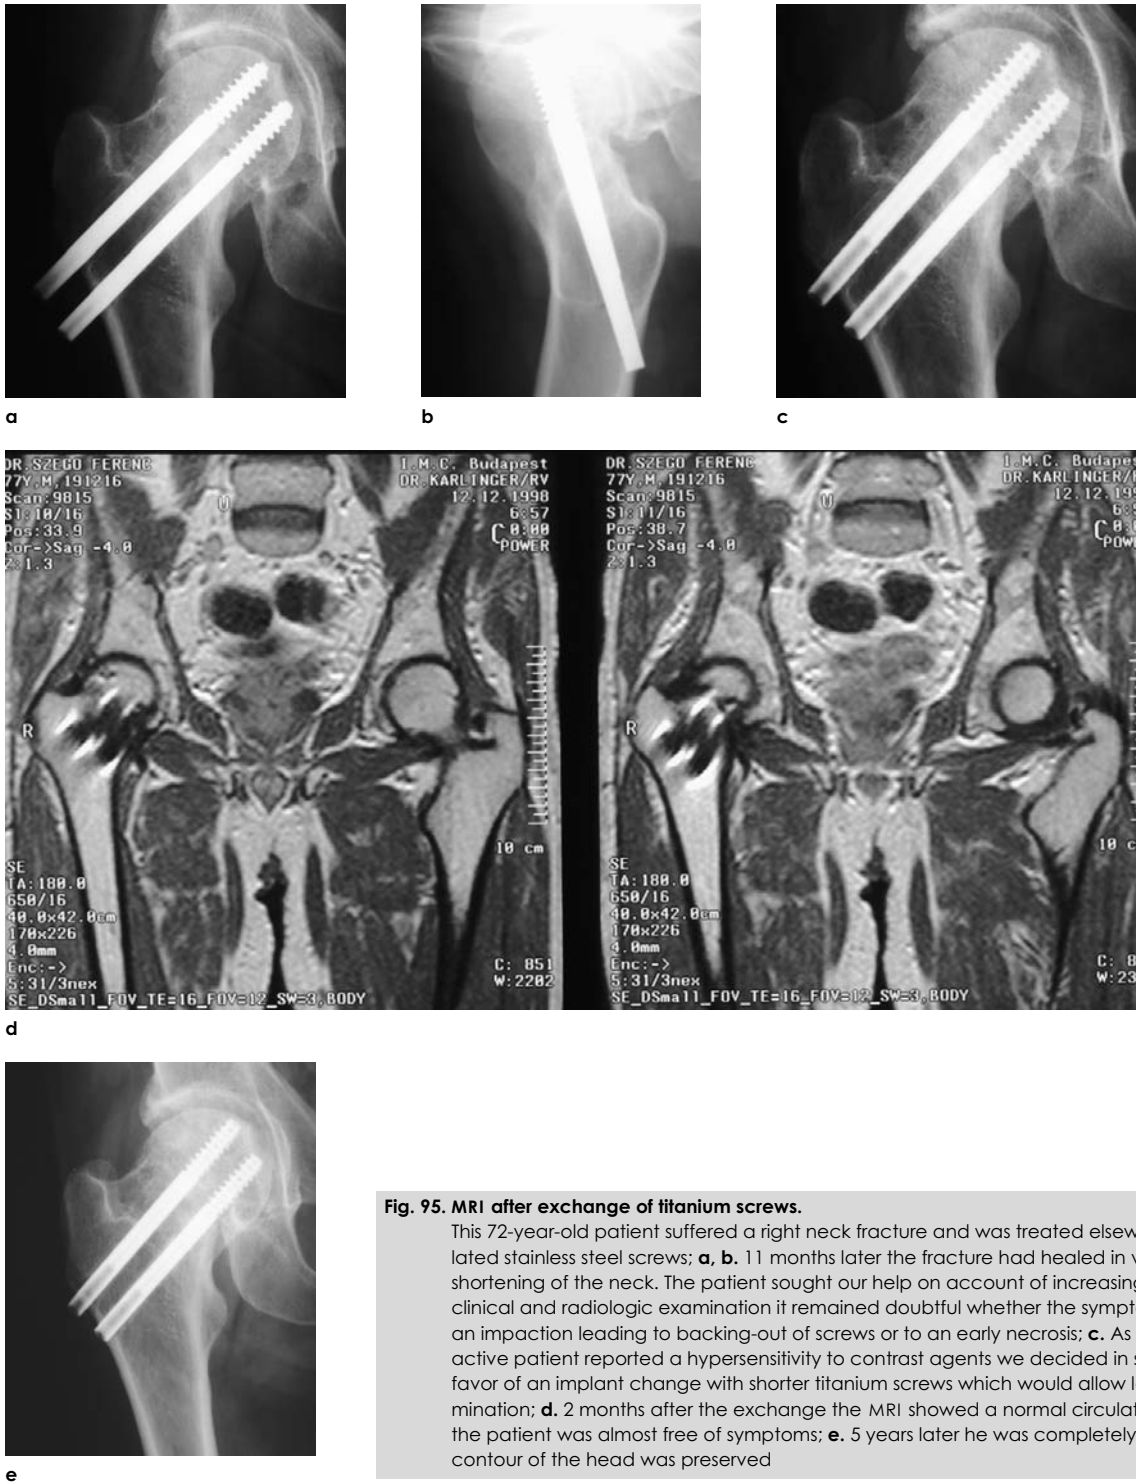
MRI after exchange of titanium screws.
